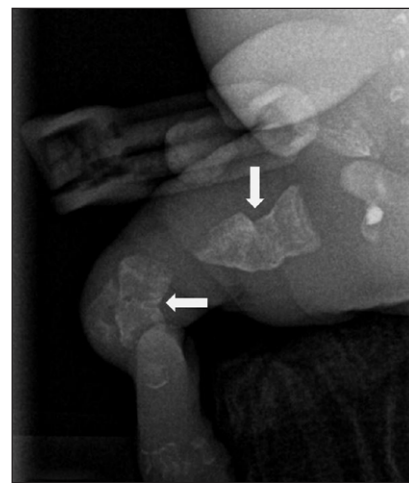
Accordion sign in osteogenesis imperfecta type II in a 24-month-old fetus. Plain radiograph of the right lower leg showing marked shortening of the long bones and accordion-like deformity.
